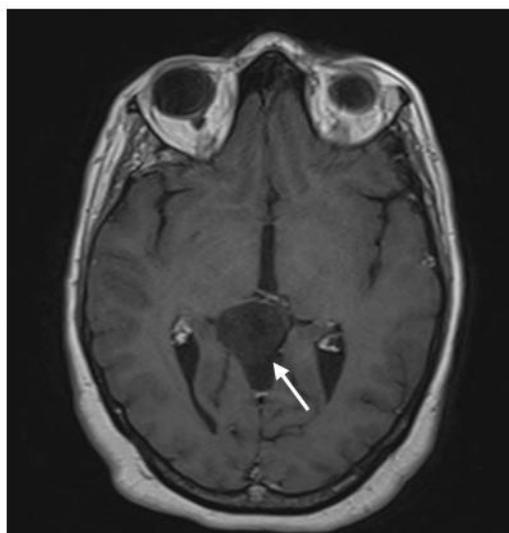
Axial enhanced T1-weighted MR image: Median process of the pineal region, rounded in shape, well limited, appearing hypointense on T1
